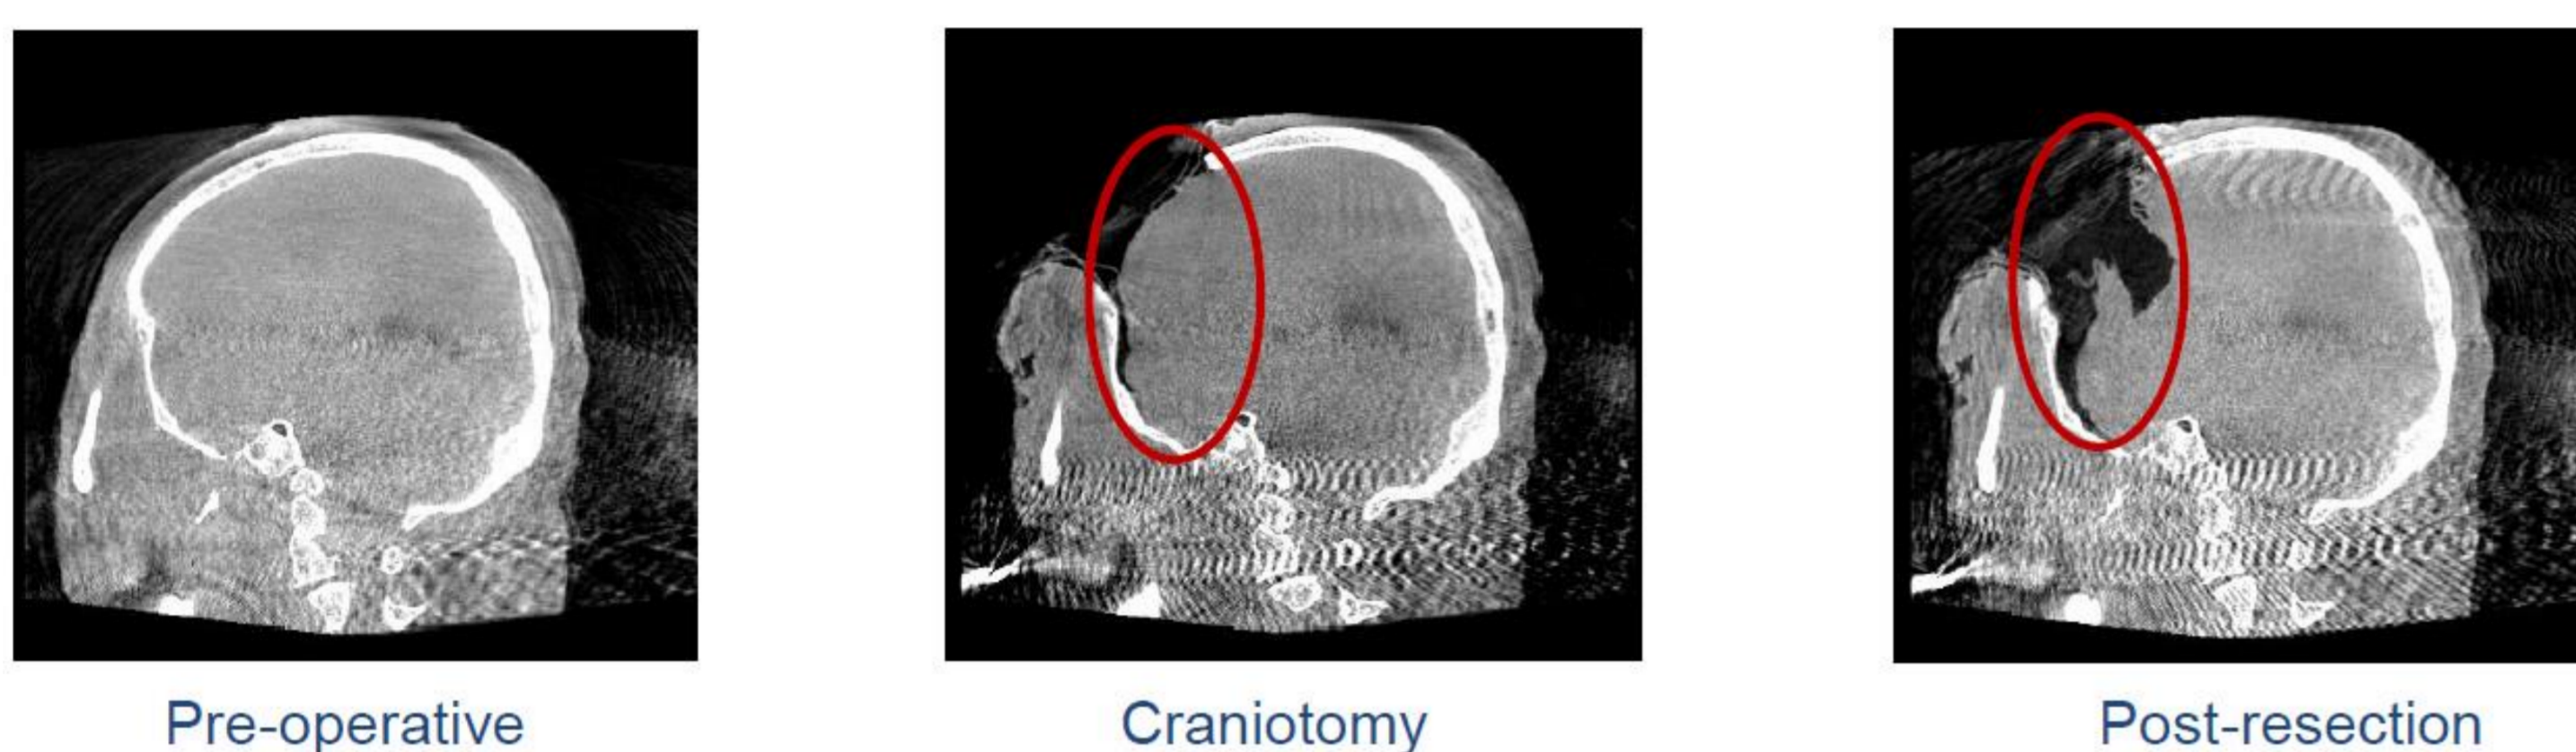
Intraoperative brain shift acquired with C-arm CT scanner in collaborating clinic.
